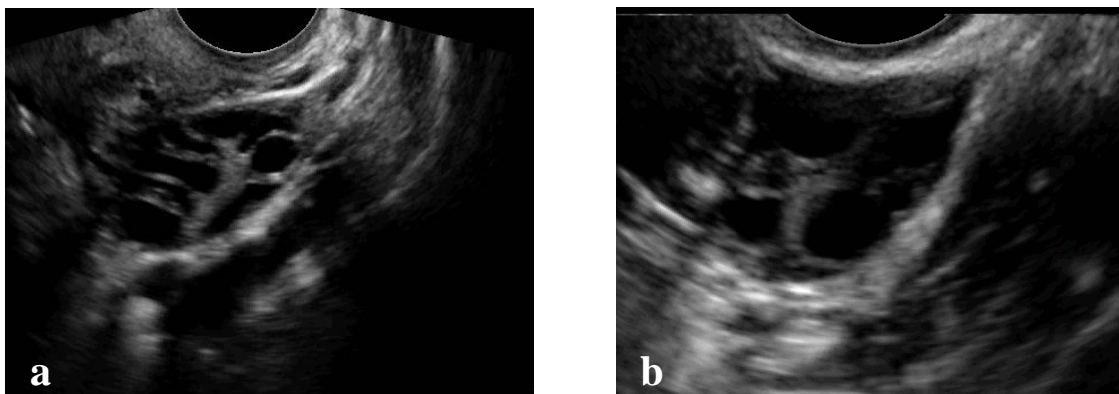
Ultrasound images of a left ovary in the transverse plane (a,b). Ultrasound image of a left ovary in the transverse plane before the intervention (a). Ultrasound image of the same left ovary in the transverse plane after the intervention (b).
